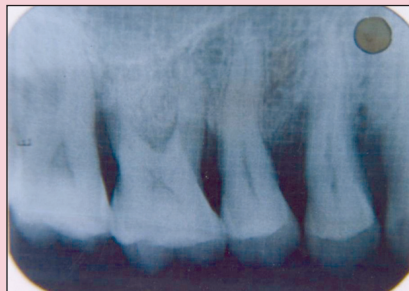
Postoperative radiograph of the control defect at 3 months.
